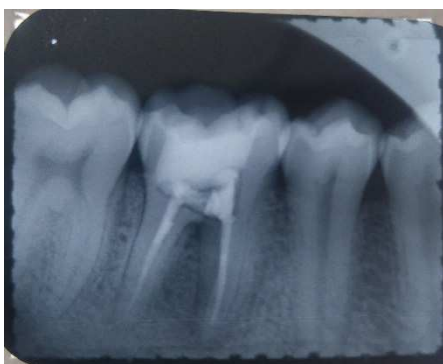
Radiograph appearance before treatment
